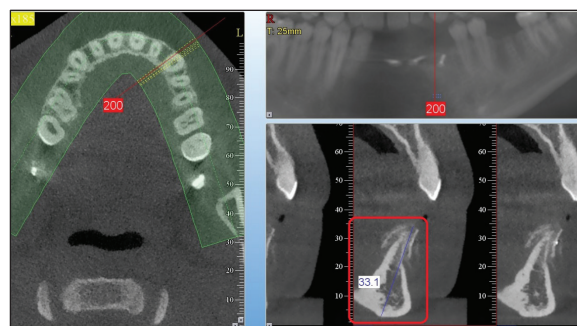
CBCT scan – measurement of the long axis.
